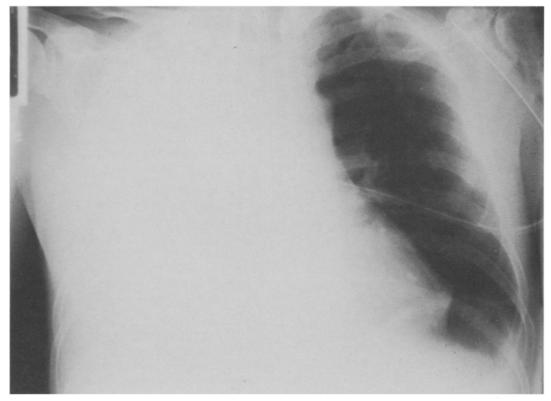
PA chest radiograph with a massive right-sided pleural effusion.
